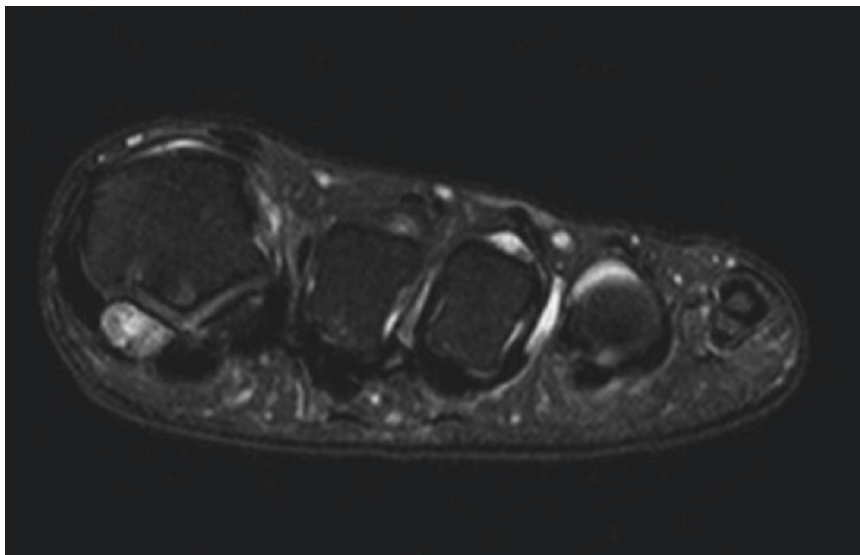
MRI demonstrating increased signal intensity on T2-weighted imaging within the tibial sesamoid in a patient with tibial sesamoiditis
